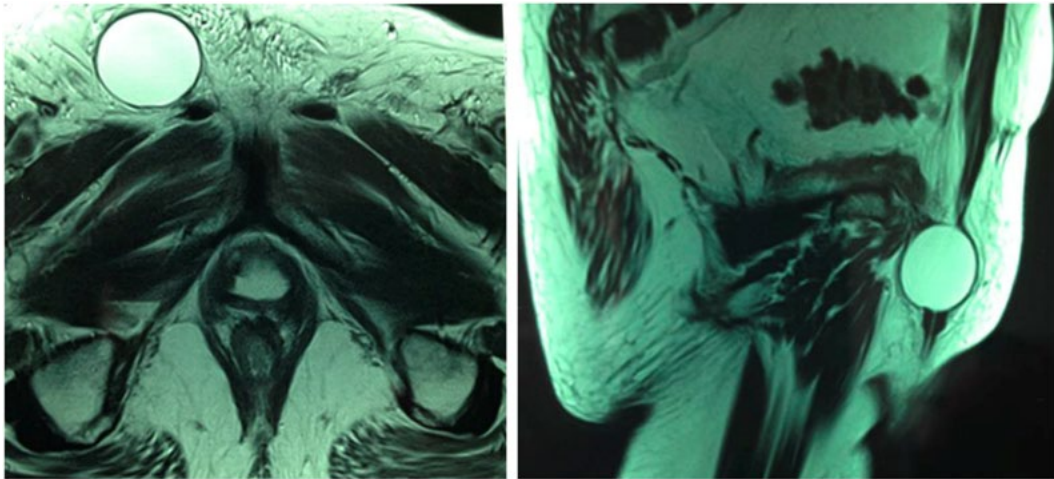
A and B: MRI demonstrating reservoir displacement through an inguinal hernia. Courtesy of Drs Luis Augusto Seabra Rios and Márcio Augusto Averbek and by permission of Urologia Essencial
